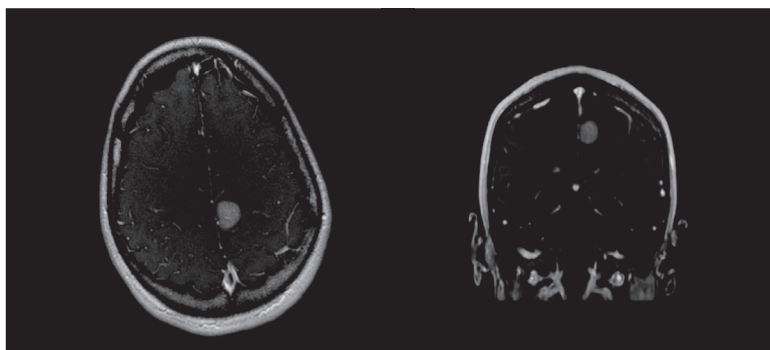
Preoperative transaxial and coronal gadolinium-enhanced MRI scan of a patient with a gangliocytoma of the postcentral gyrus.
